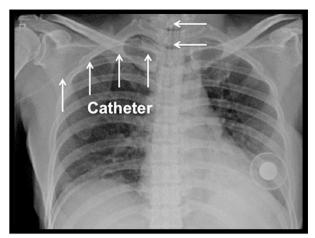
Chest X-ray after insertion of the PICC catheter. The catheter moved in the cranial direction.
